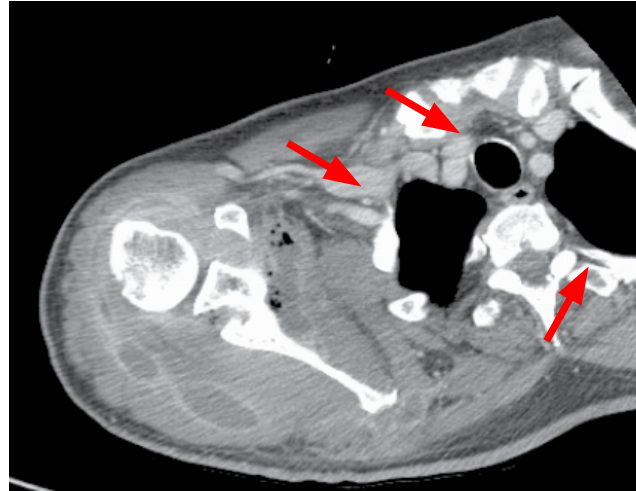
CT of left shoulder with multiple images of gas density inside.
